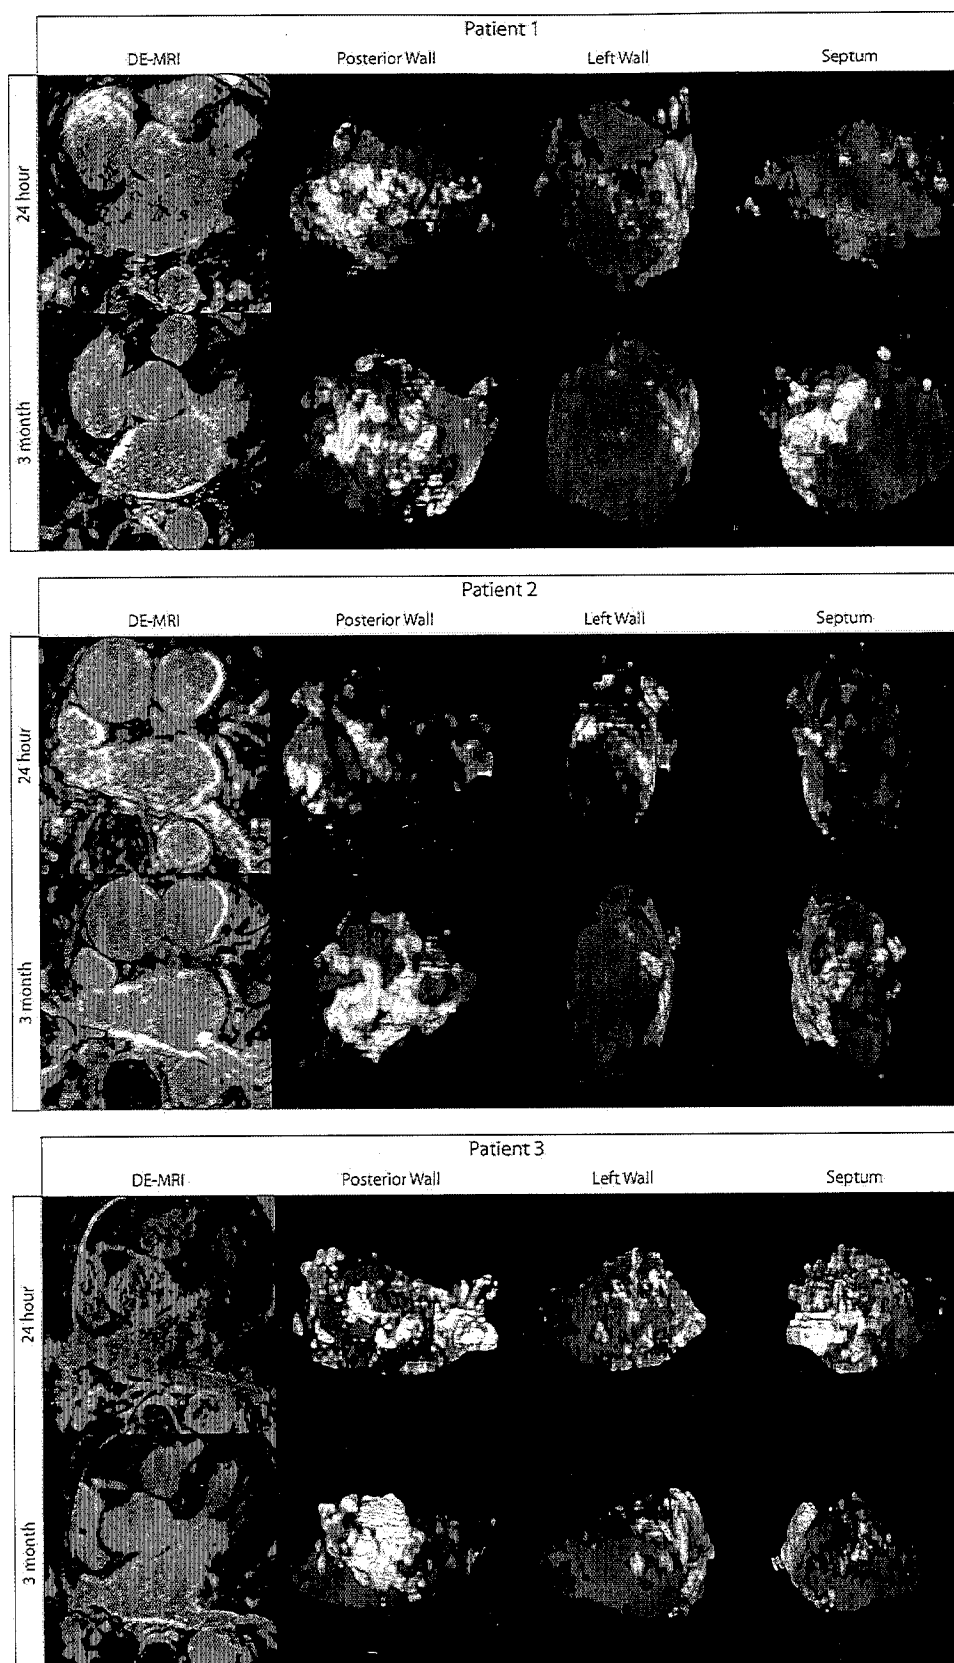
Three-dimensional DE-MRI analysis of scar patterns of three patients at 24 hours (*top row*) and 3 months (*bottom row*) post-PVAI. Twenty-four hour MRI shows diffuse and less intense enhancement patterns with a substantial reduction in algorithm-detected scar at 3 months. There is also substantial enhancement in regions not targeted during the ablation such as the anterior wall (*top right*) that appears to resolve by 3 months. Also at 3 months, LA scar patterns appear to be in well-demarcated scar borders along the posterior wall and around the PV antrum.
